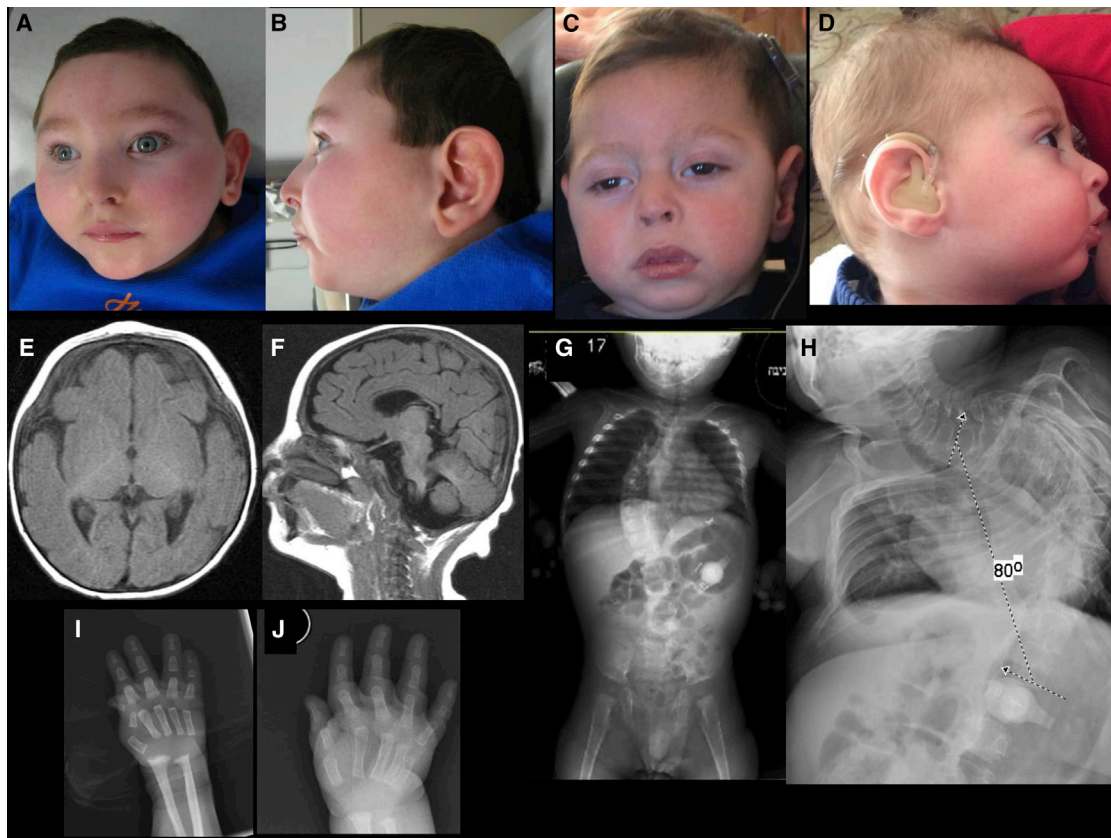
Clinical and Radiographic Findings
